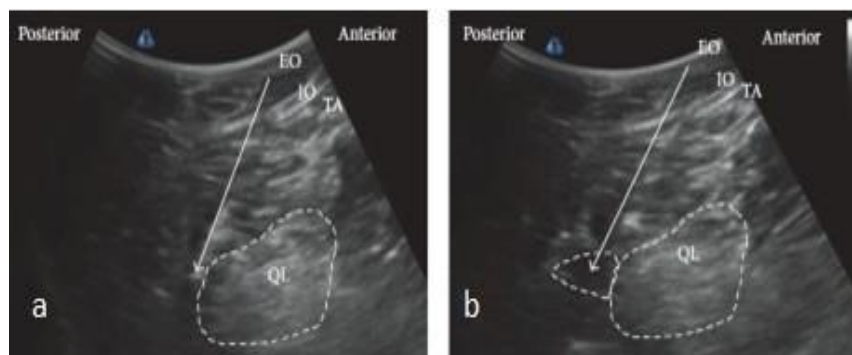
Ultrasound images of posterior Quadratus lumborum block approach: (a) Pre-injection and (b) post-injection. EO: external oblique muscle, IO: internal oblique muscle, TA: transversus abdominis, QL: quadratus lumborum, white arrow: needle trajectory and white dotted line: the spread of local anesthetic (36).
